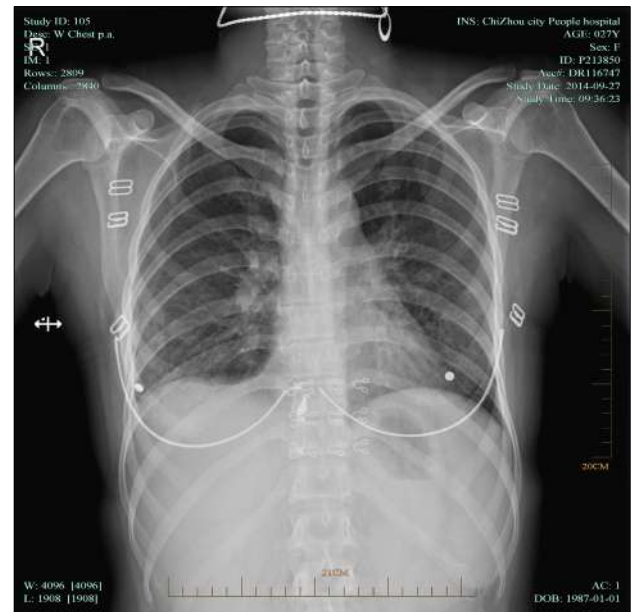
Chest radiograph, showing that the double lung texture disorder and bilateral pleural effusion had disappeared.
